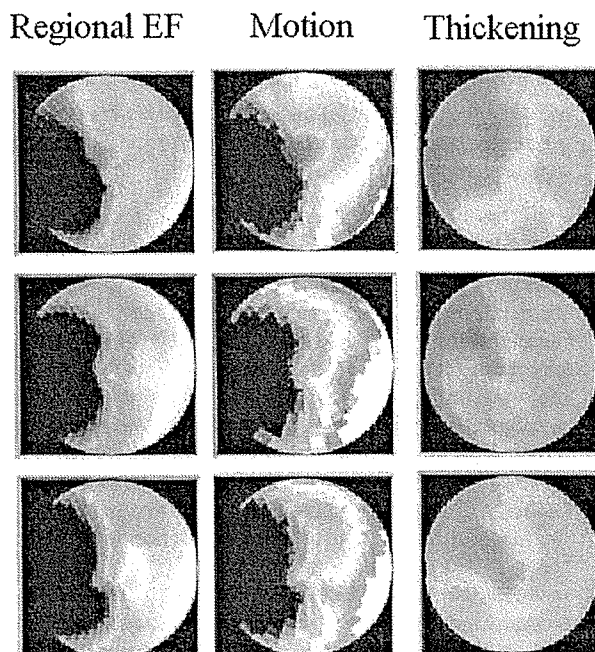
Technetium (Tc 99m)-tetrofosmin-gated single photon emission computed tomography. (Upper panels) Thirty-seven days after left ventricular assist device (LVAD) implantation and two coronary artery bypass grafts. (Middle panels) Twenty-nine days after mononuclear cell transplantation. (Lower panels) Twenty-five days after LVAD explantation (57 days after mononuclear cell transplantation).
